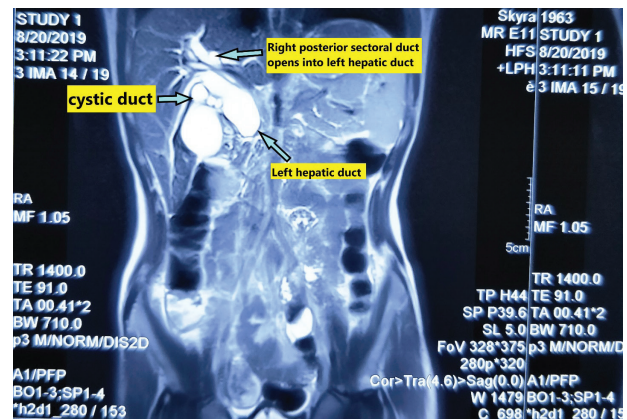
MRI photograph showing hepatic duct anomaly type IIIa showing the right posterior sectoral duct opening into the left hepatic duct.
